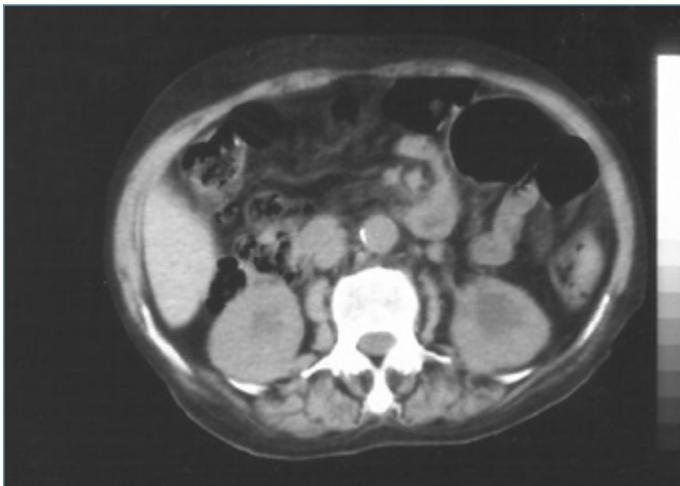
Bilateral hydronephrosis is observed in CT
